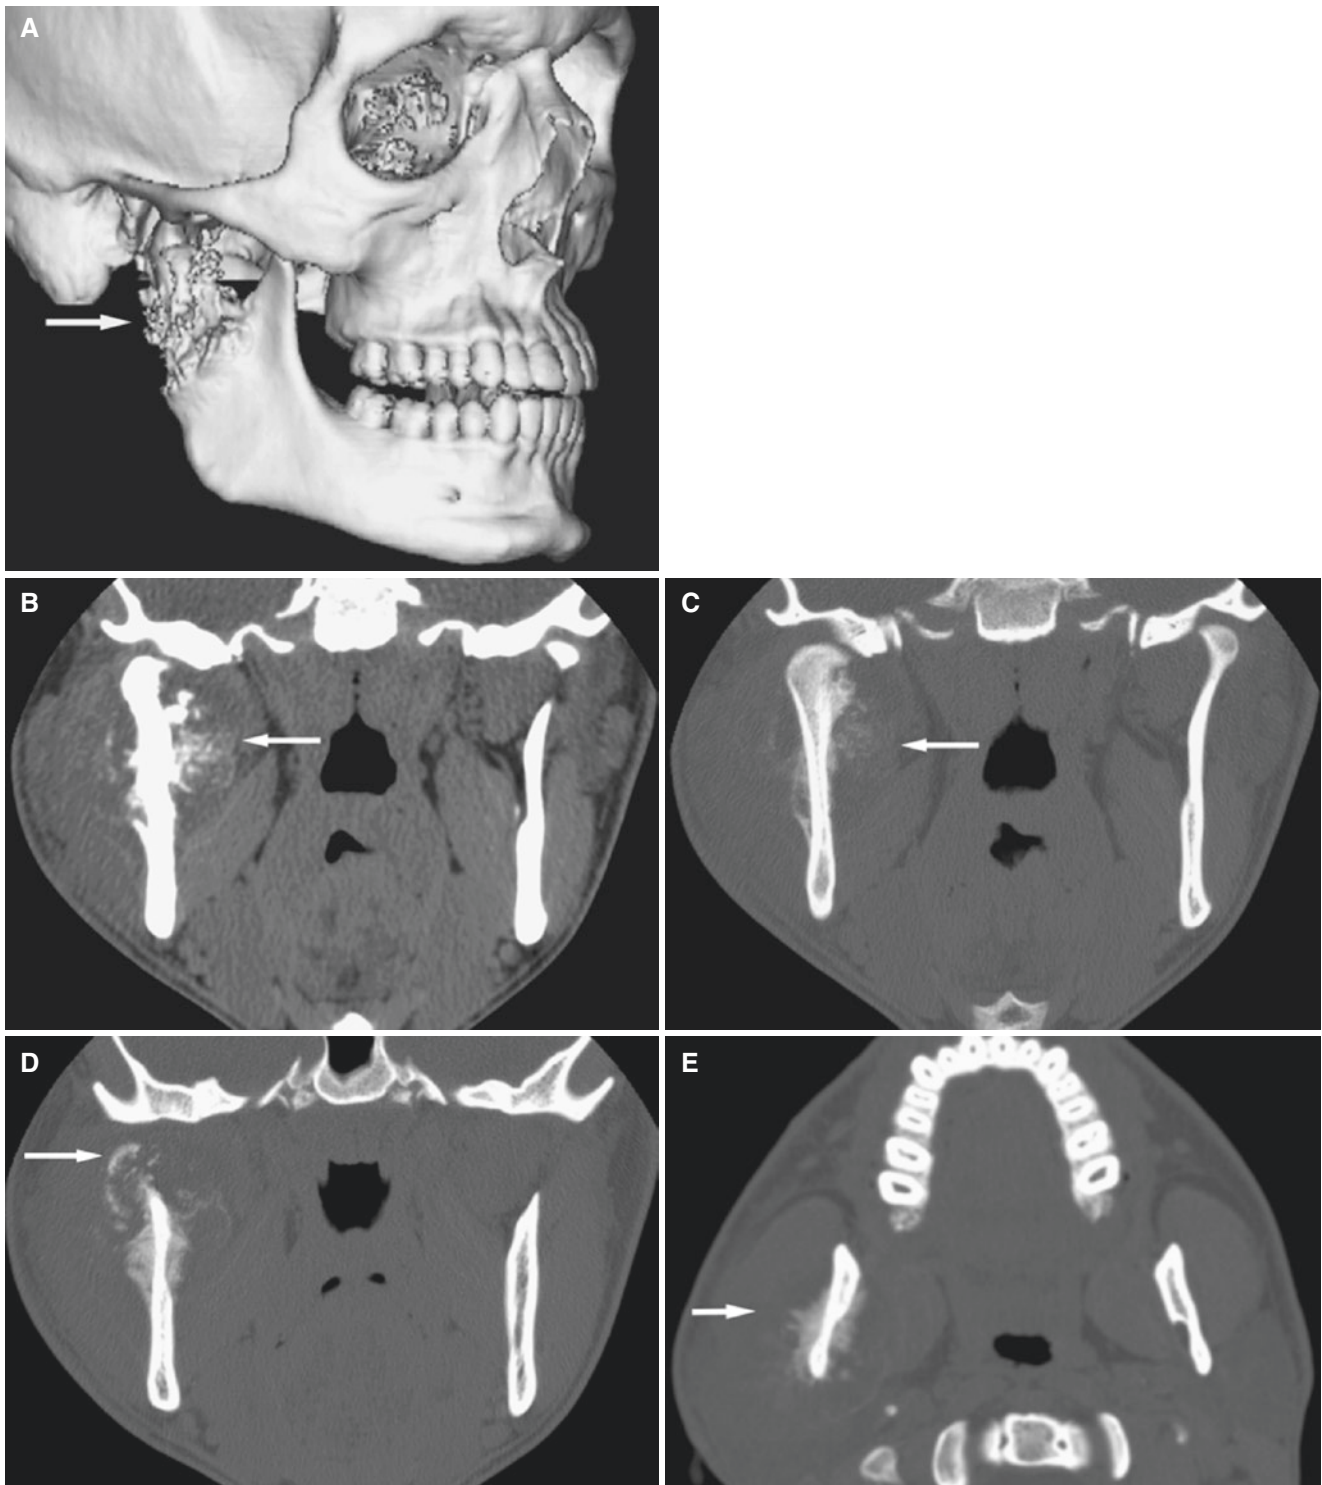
Chondrosarcoma, mandible; 19-year-old male with facial swelling, no pain. (A) 3D CT image shows tumor in the right mandibular collum (*arrow*). (B) Coronal CT image, soft-tissue window, shows soft-tissue mass around ramus (*arrow*). (C) Coronal CT image shows
